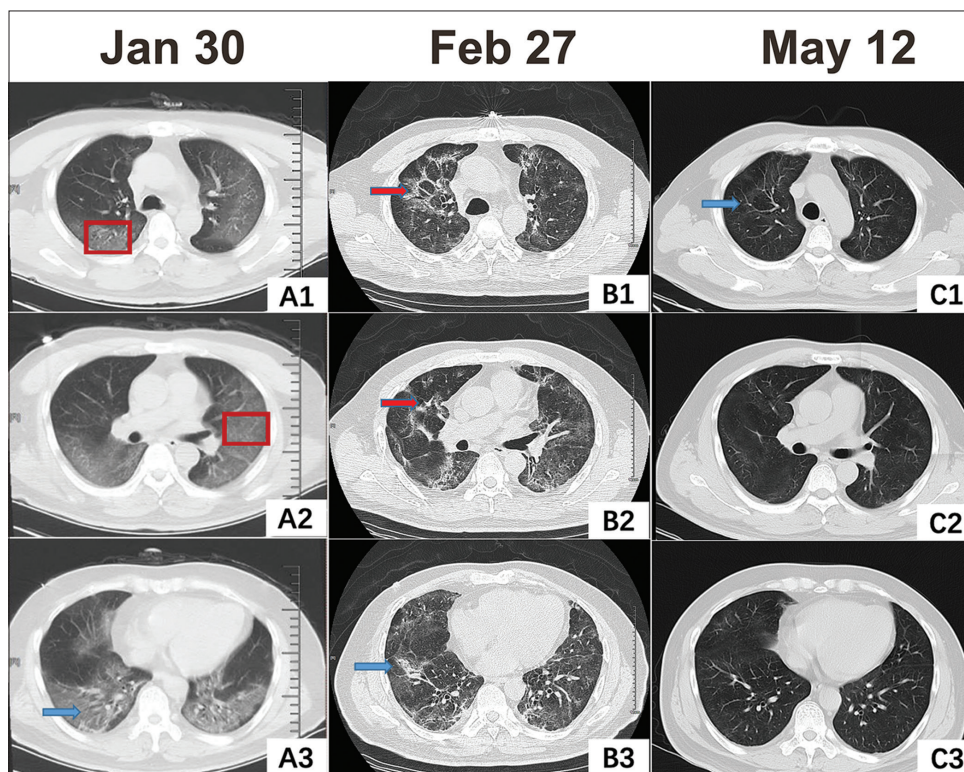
The patient presented with typical ground glass opacities on admission (A1-A2, red boxes). Follow-up computed tomography images demonstrated progressions of multiple ground-glass opacities and ground-glass opacities with interlobular septal thickening (B1-B2, red arrow) a month after hospitalization. C1-C3 showed that the early consolidation was almost completely absorbed.
